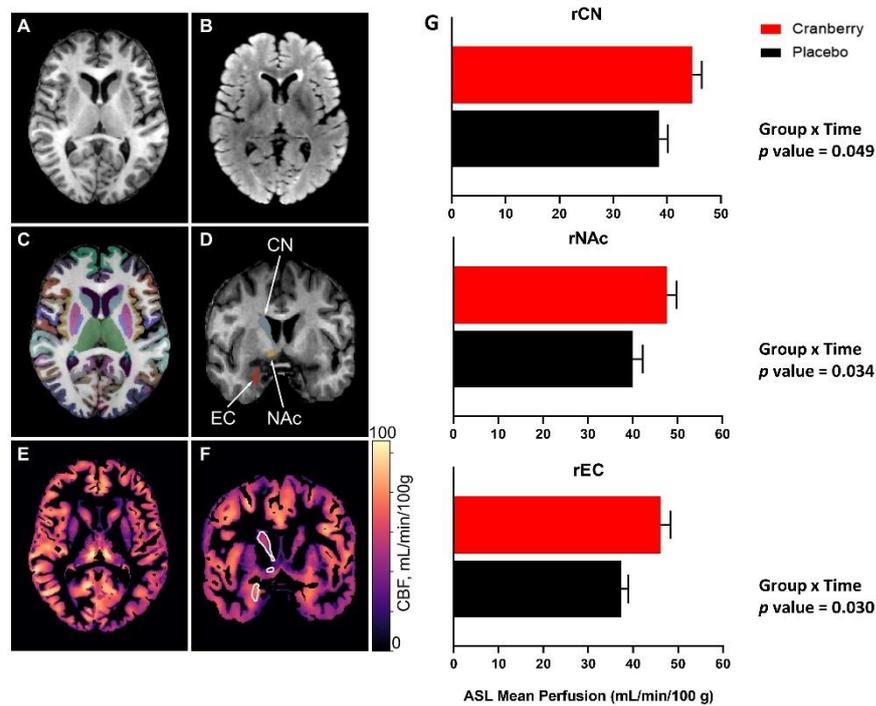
Representative magnetic resonance imaging data from this study, obtained in a 61-year-old male/female subject (COMBAT_041 baseline). A) axial T1-weighted inversion recovery fast spoiled gradient echo (IR-FSPGR) image; B) axial T2-weighted fluid attenuated inversion recovery (FLAIR) image; C) an axial view of FastSurfer cortical and subcortical segmentations superimposed on a T1-weighted image; D) a coronal view of the T1-weighted image indicating regions that showed significantly increased perfusion after 12 weeks consumption of cranberry extract—namely, from superior to inferior, the right caudate nucleus, accumbens area, and entorhinal cortex; E) an axial cerebral blood flow (CBF) map, in the T1 space, derived from arterial spin labeling data; F) a coronal CBF map highlighting the regions indicated in D, and G) differences in mean blood perfusion for the right caudate nucleus (rCN), right nucleus accumbens (rNAc) and right entorhinal cortex (rEC), with p values represented
